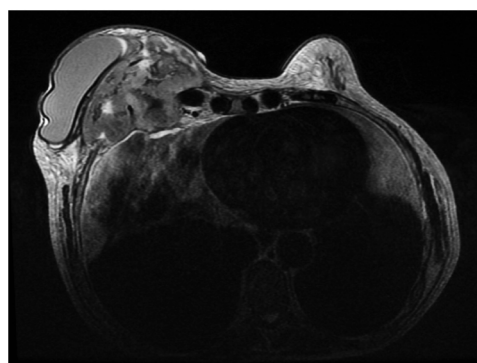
Magnetic resonance image of a retroprosthetic lobulated mass measuring 14 × 10 × 7 cm with irregular margins in addition to peripheral enhancement and central necrosis and invasion of the chest wall through to the mediastinum.
